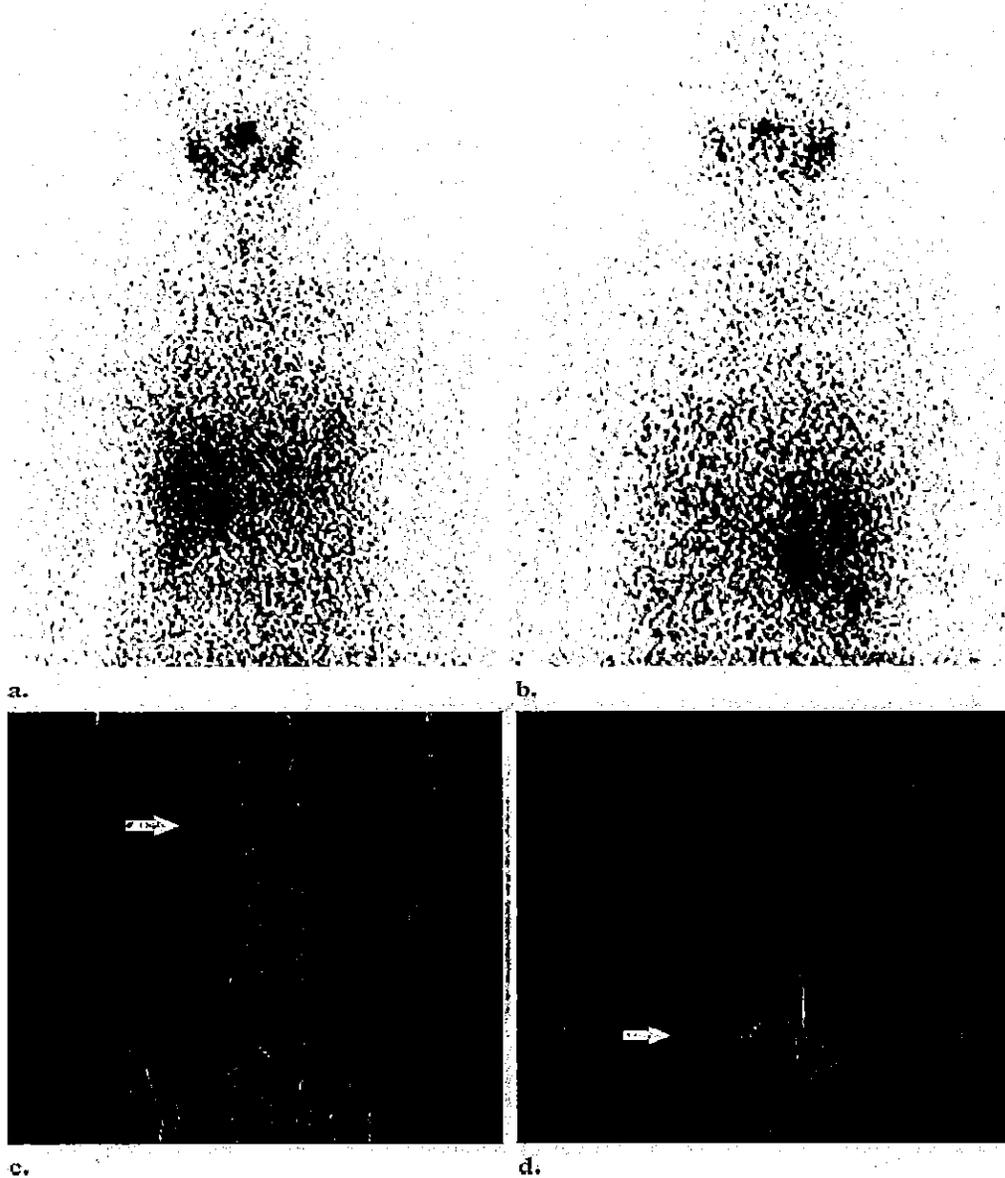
Differentiation between malignancy and benign changes with SPECT/CT in a patient with thyroid cancer who underwent whole-body ¹³¹I scanning to assess for residual recurrent disease. (a, b) Anterior (a) and posterior (b) ¹³¹I scans show focal activity in the right suprarenal region. (c, d) Coronal (c) and axial (d) SPECT/CT images show that the uptake is located in the renal collecting system (arrow), a finding consistent with physiologic urinary activity.
